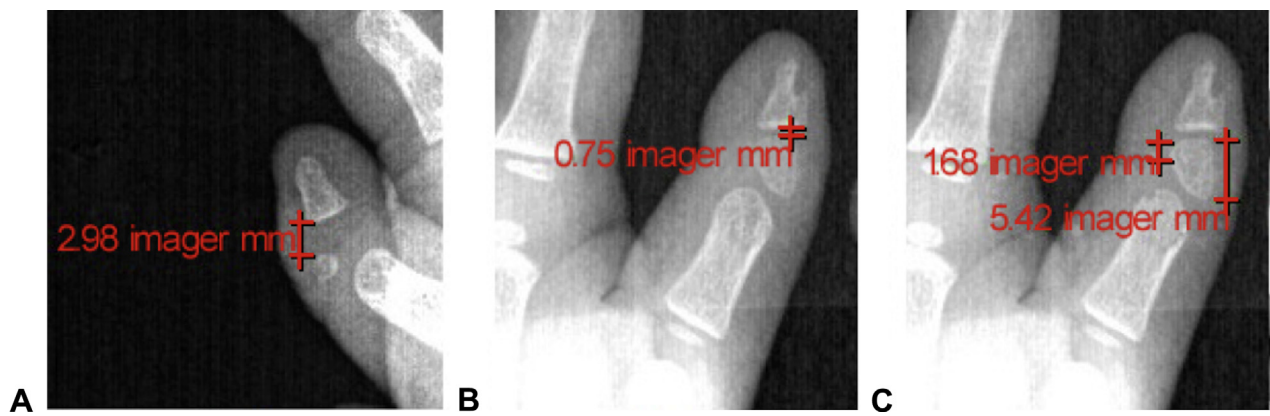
Measurements obtained on radiographs in representative patients. Distance measured between the ossification center and the distal phalanx in a A triphalangeal thumb (2.98 mm) and B obvious hypertrophic epiphysis (0.75 mm). C The length of the ossification center on the radial (5.42 mm) and ulnar (1.68 mm) side was measured.
